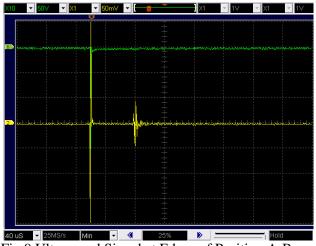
Ultrasound Signal at Edges of Position A-B
